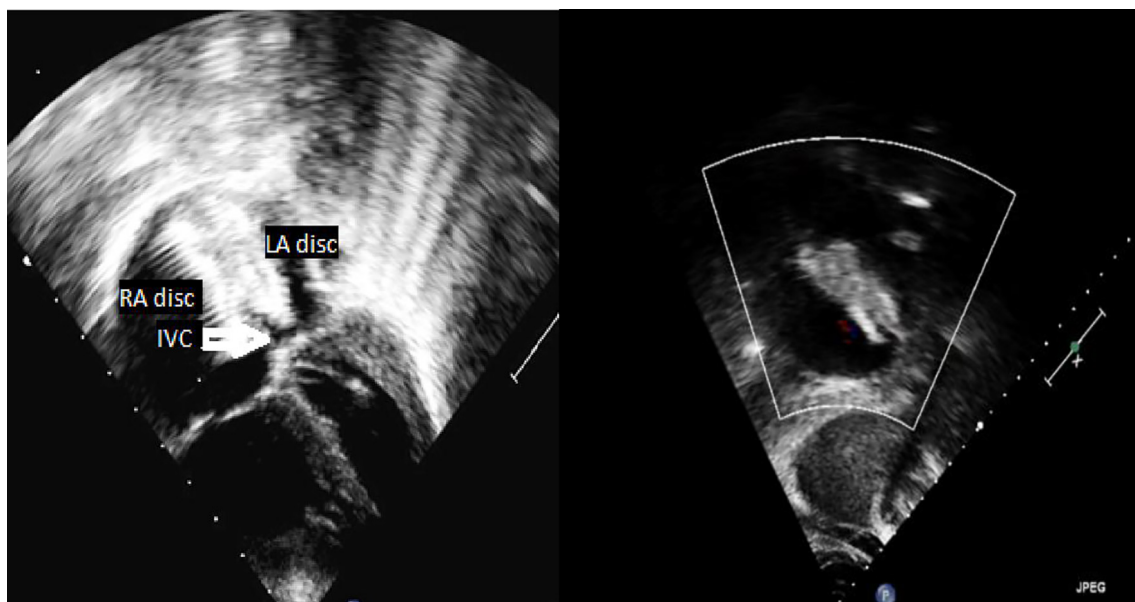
Using transthoracic echo during the procedure; the device in good position after releasing the occluder in 4-chamber and subcostal views.
